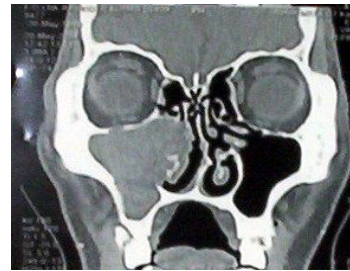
CT scan image showing the involvement of nasal cavity and maxillary sinus
